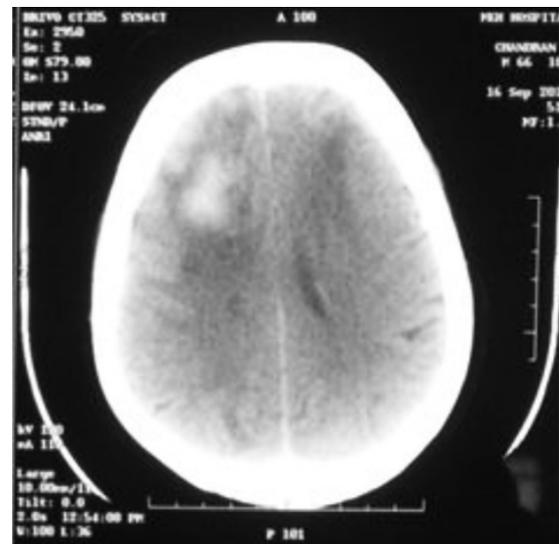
CT head showing a well defined hyperdense lesion with irregular margins in right frontal lobe with surrounding edema and mass effect
